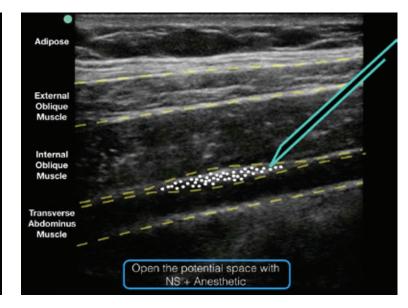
An ultrasound representation demonstrating where anesthetic should be placed when performing a TAP block.
